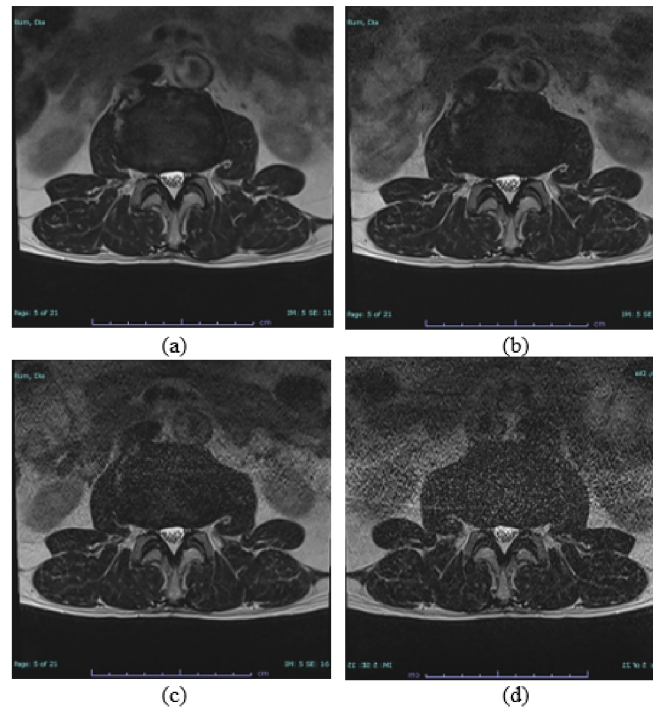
Image result of Lumbar MRI Axial cut T2WI TSE using GRAPPA Acceleration Factor variation (a) without GRAPPA (we designate this as AF 1) (b) GRAPPA AF 2 (c) GRAPPA AF 3 (d) GRAPPA AF 4
